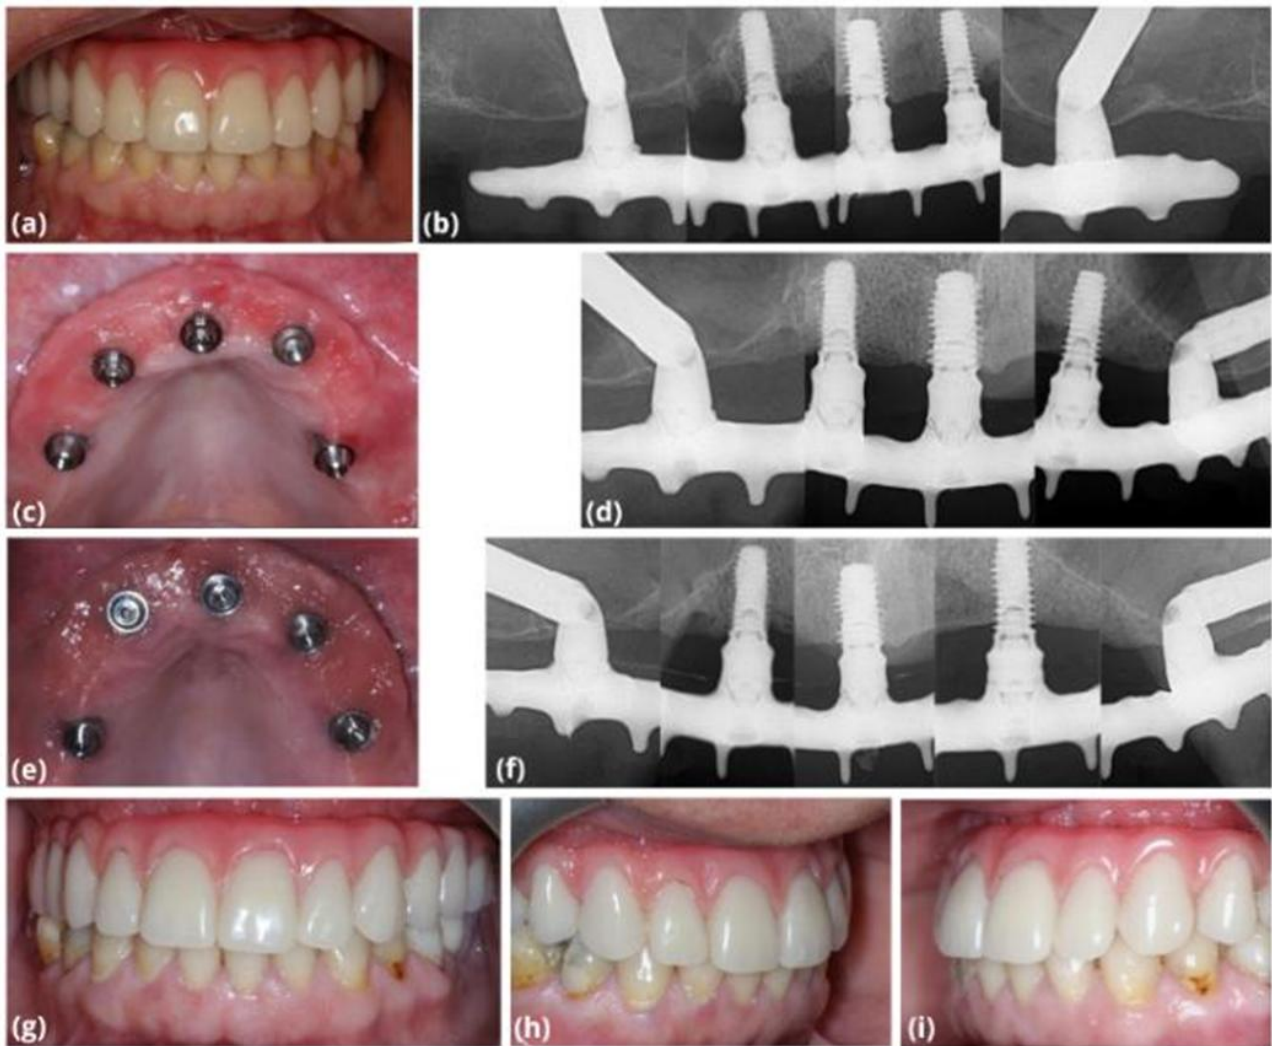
Clinical and radiographic conditions: Final definitive prosthesis delivered at 48 hours postoperatively. (a-b); 1-year follow-up (c-d); 4-year follow-up (e-i).
